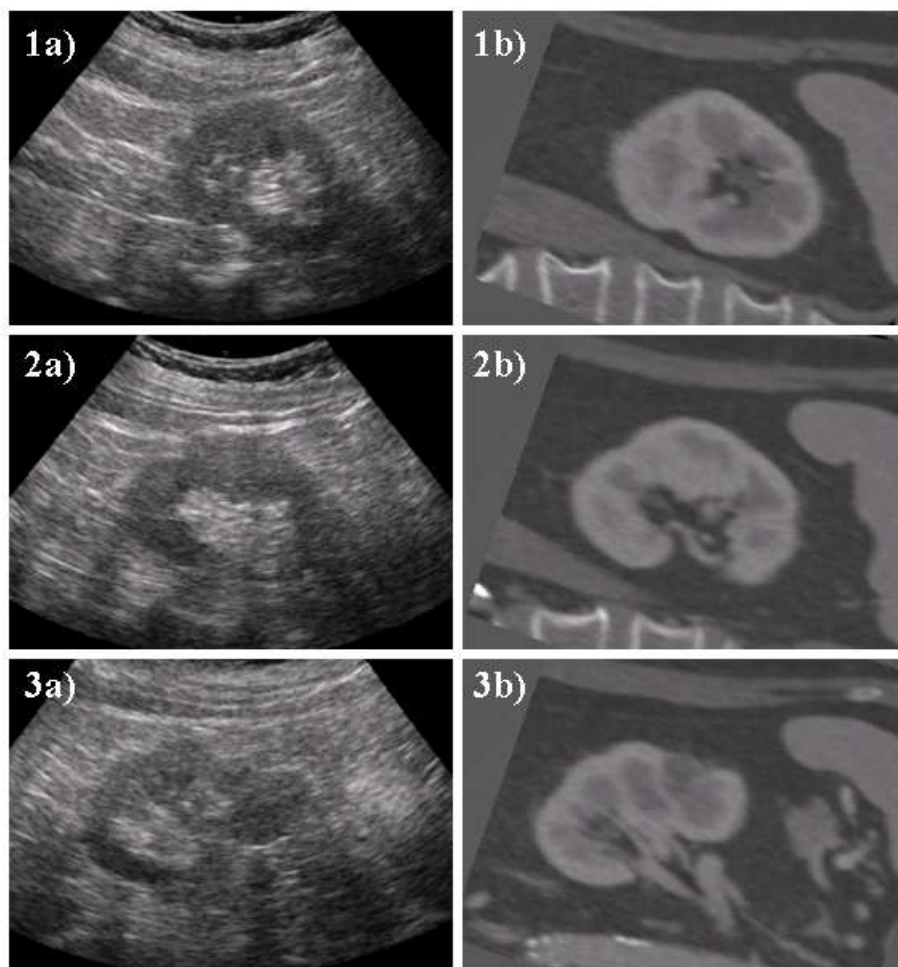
Various slices of a volumetric dataset from a single patient. Volumes are aligned using PCA as the bronze standard. Pairs of corresponding US and CT slices are shown in each row.
